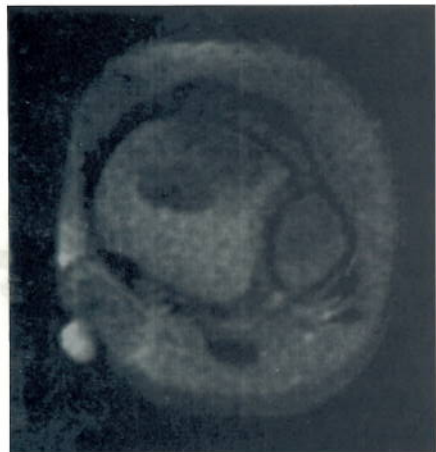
The pre-gadolinium transverse T1-weighted FatSat scan demonstrated a somewhat homogeneous soft-tissue mass, directly beneath the liquid-filled skin marker.
